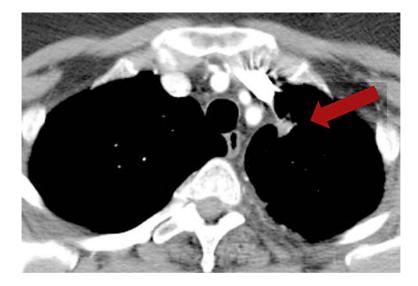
Chest CT scan. Objective response after 2 months of afatinib (arrow; see fig. 2 for baseline).
